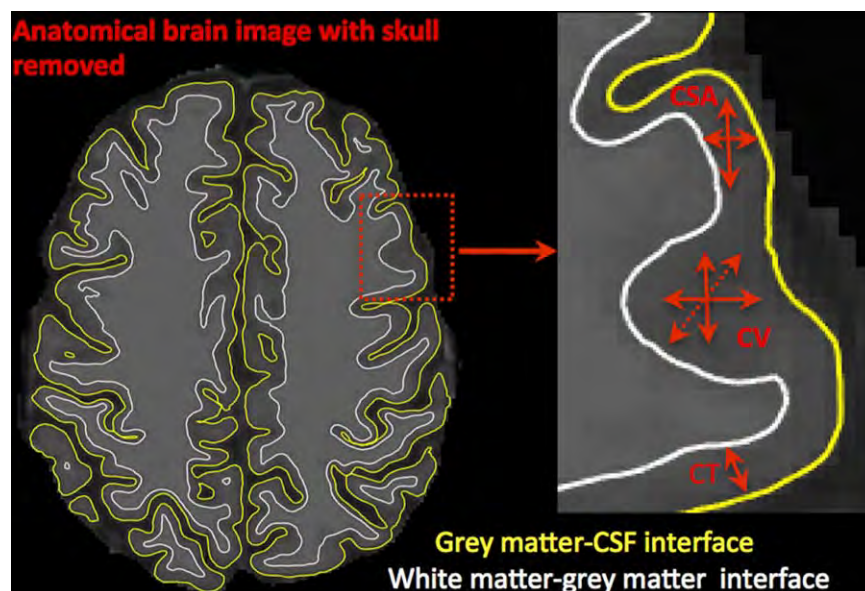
Cortical thickness (CT), cortical volume (CV), and cortical surface area (CSA). Representation of cortical measures (CT, CV, and CSA) within original anatomical brain image [Color figure can be viewed at wileyonlinelibrary.com]
